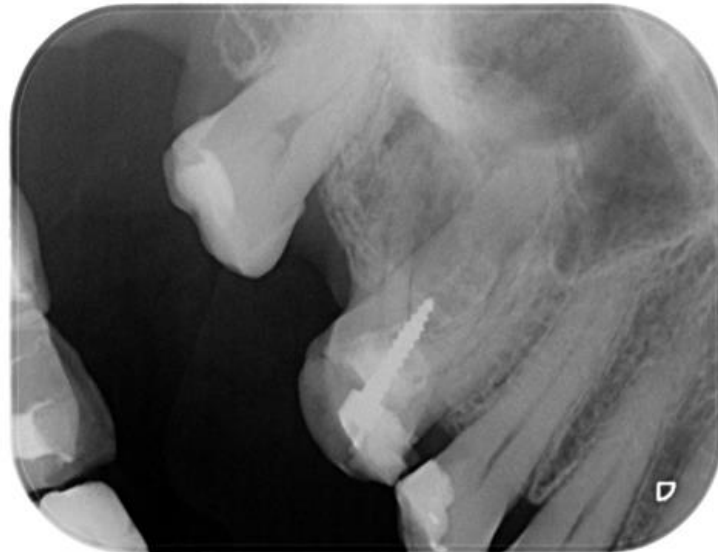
Case 4. Pre operative x-ray showing a not ideal root canal treatment and a restoration with a “dentatus” post on the palatal canal. The post was placed too buccally, perforating the root
